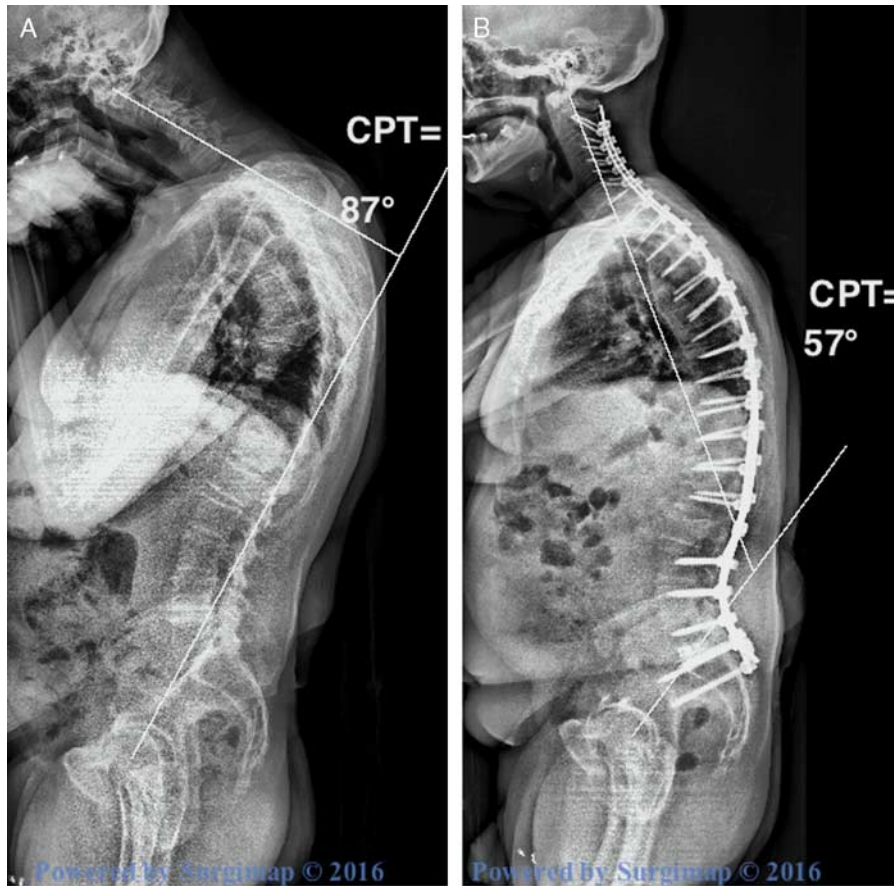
Full spine radiographs in a cervical deformity patient depicting preoperative (A) and postoperative (B) the C2 pelvic tilt (CPT) angle. A larger CPT angle corresponds to worse deformity.
